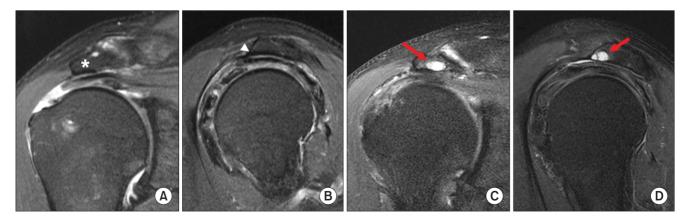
Cyst in the acromion. (A) Preoperative T2-weighted oblique coronal magnetic resonance (MR) image showing no high signal intensity lesion in the acromion (asterisk). (B) Preoperative T2-weighted oblique sagittal MR image showing a mild anterior spur (arrowhead). (C) Postoperative T2-weighted oblique coronal MR image showing a high signal intensity cystic lesion (arrows) in the acromion. (D) T2-weighted oblique sagittal MR image.
